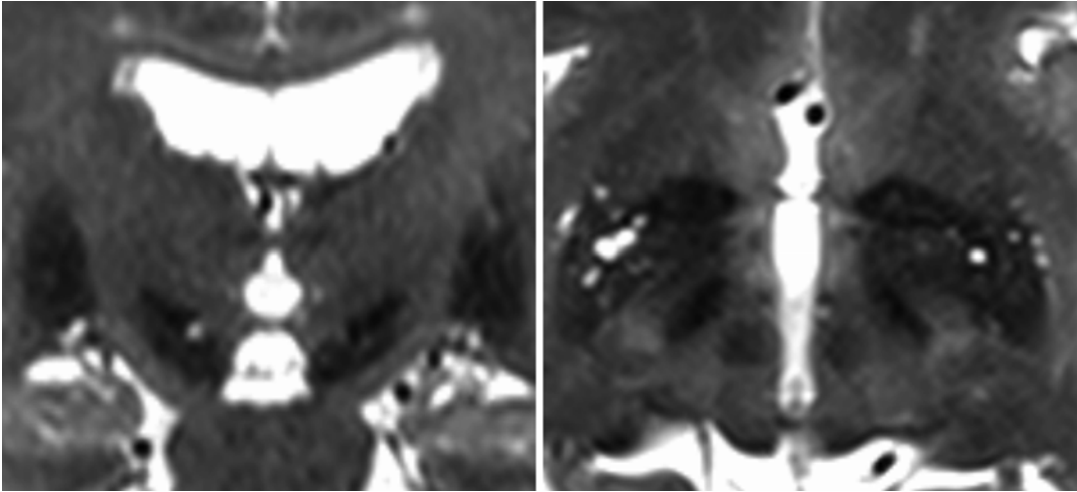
T2 fast spin-echo images by 3T MRI demarcate the subthalamic nucleus or pallido-internal capsule border, which may offer reliable targeting
